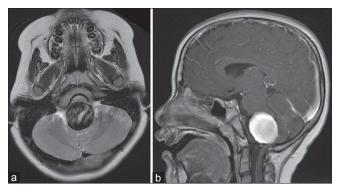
T2-weighted MR imaging shows a giant aneurysm as a flow void signal, compressing the brainstem with edema (a) GdenhancedT1-weighted imaging shows homogeneous enhancement aneurysm (b) T2-weighted MR imaging shows a giant aneurysm as a flow void signal, compressing the brainstem with edema
